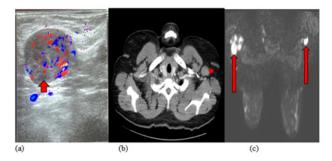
Ultrasound (a), axial CT (b) and axial MRI images showing the enlarged left axillary lymph nodes which show vascular flow and are rounded on USS (short arrow) and CT (arrowhead) and show restricted diffusion on MRI (long arrow).
